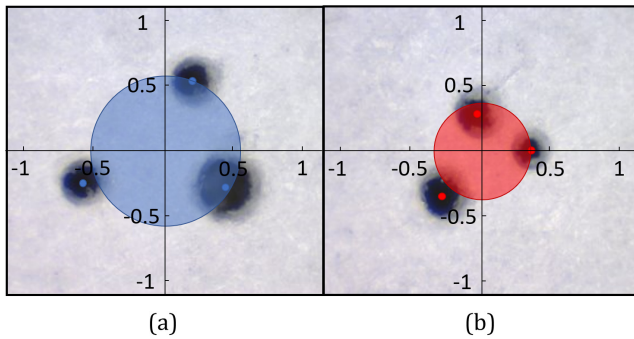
Puncture distribution of MRI experiments, with the origin as the mean of the points and the large circle representing the standard deviation. (a) shows the NR punctures and (b) shows the SR punctures. Units in mm.
